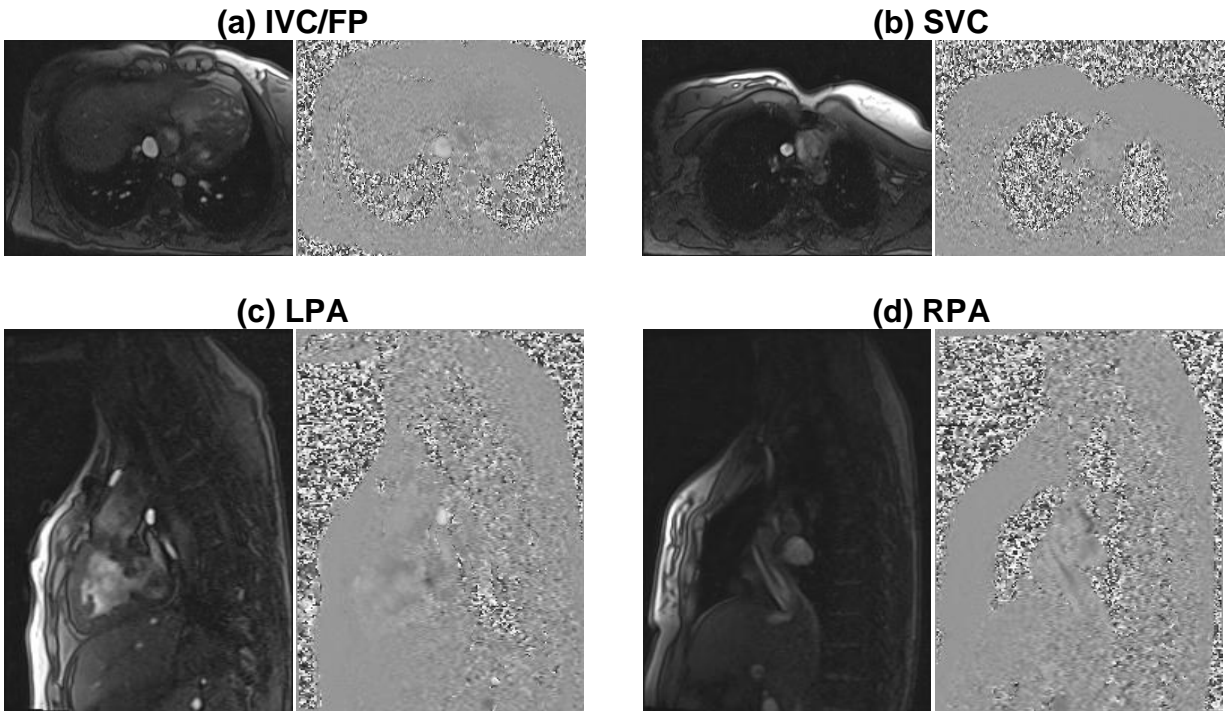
Example of resting PC-MRI images at the (a) IVC/FP, (b) SVC, (c) LPA and (d) RPA. The black and white image on the left shows the magnitude image, and the adjacent grey image is the corresponding phase image.
